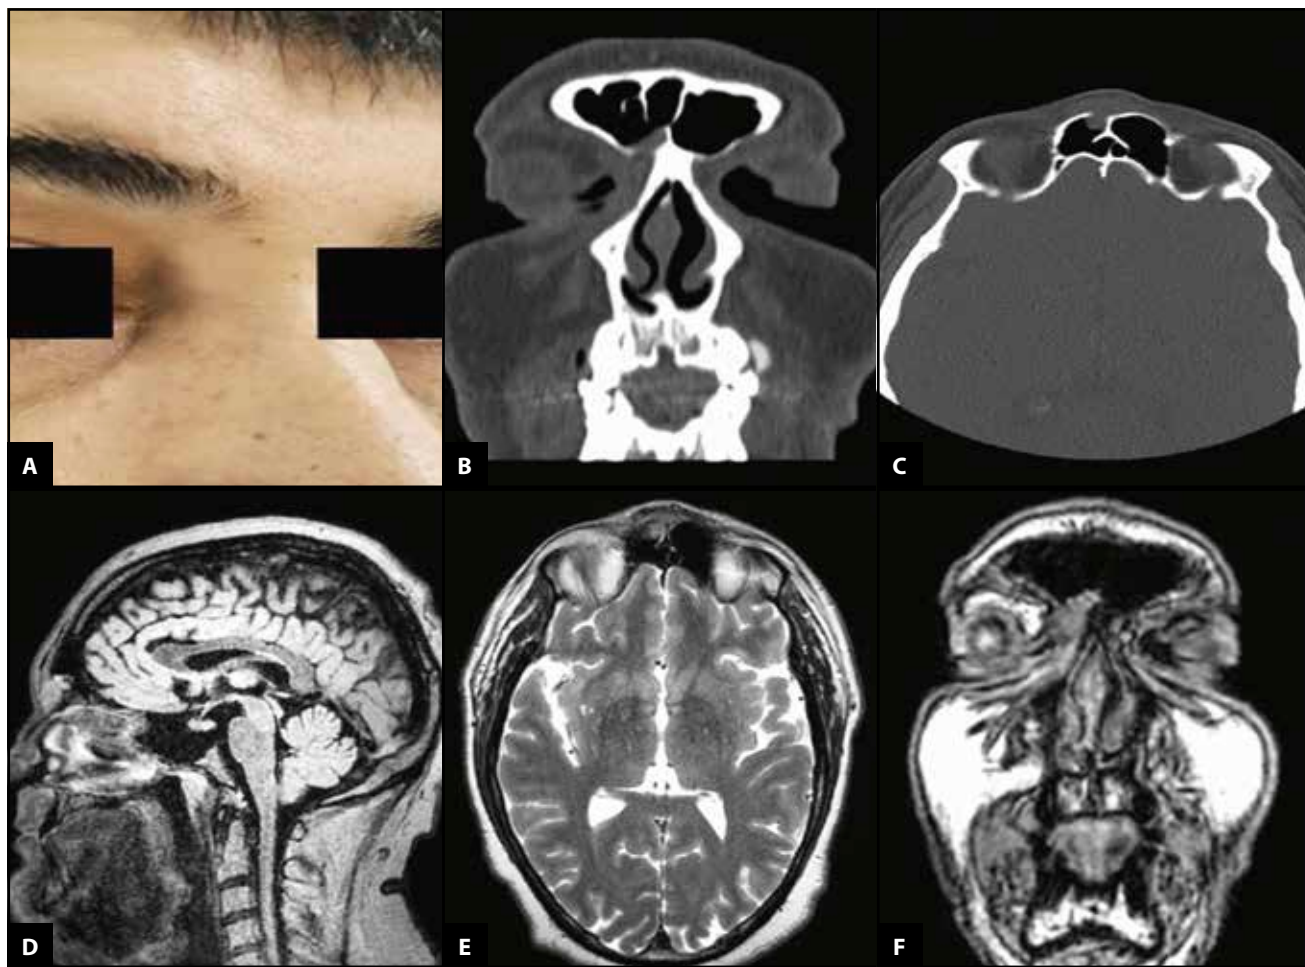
Macroscopic aspect of the lesion with integrity of the cutaneous tissue and no signs of inflammation (A). Cranio-facial CT scan, coronal (B) and axial view (C), and cranio-facial MRI sagittal (D), axial (E) and coronal view (F), revealing the lysis of the anterior wall of the right frontal sinus and the extension of the mass into the frontal sinus.
